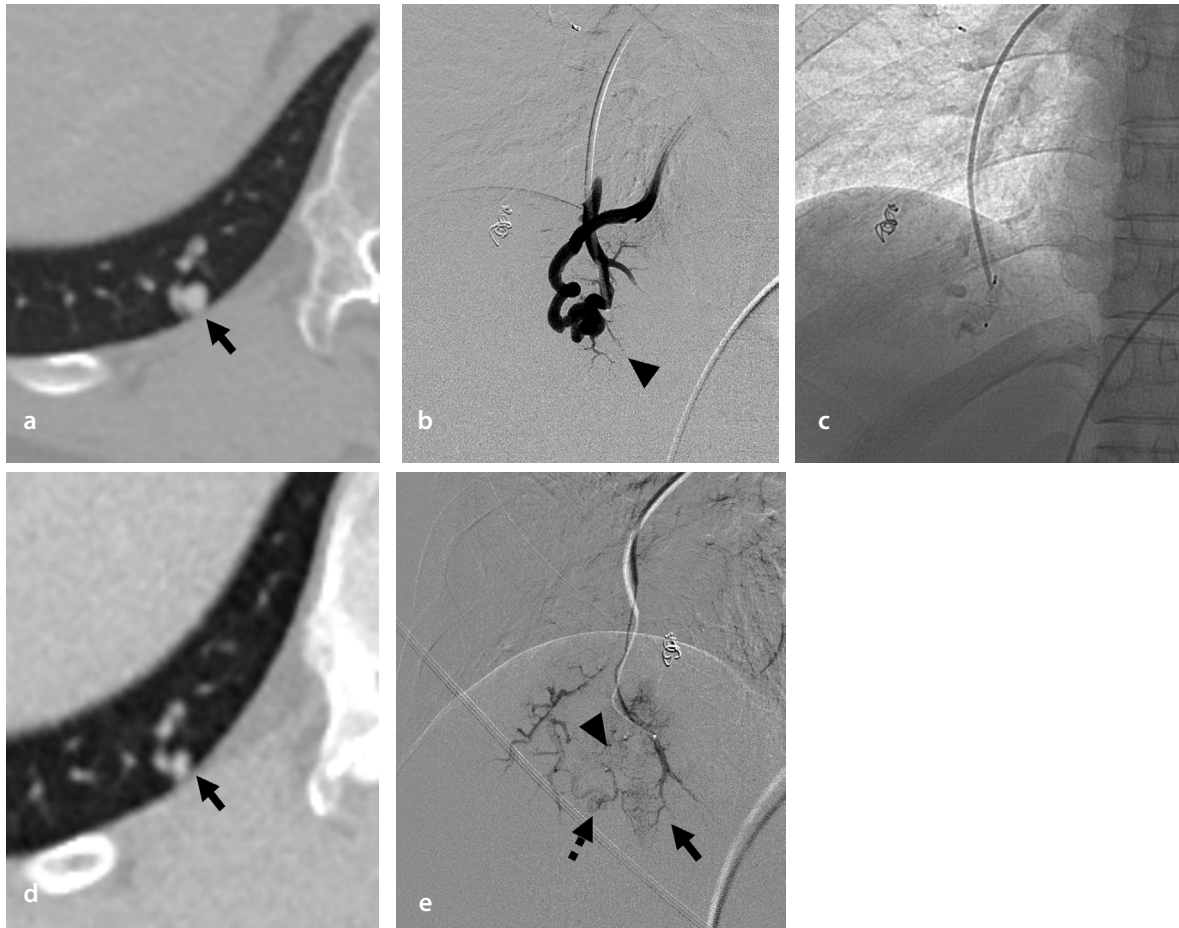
A 57-year-old woman with definite hereditary hemorrhagic telangiectasia and multiple pulmonary arteriovenous malformations (PAVM) (at least 6) in both lungs. (a) Pre-embolization computed tomography (CT) image shows a simple PAVM in the right lower lobe. The vessel diameters are as follows: feeding artery, 3.12 mm, and venous sac (arrow), 4.75 mm. (b) Angiography conducted after superselecting the distal feeding artery shows a simple PAVM. The last normal branch of the pulmonary artery is identified within the venous sac (arrowhead). (c) A 5 mm Amplatzer Vascular Plug 4 is deployed in the juxta sac-feeding artery of the PAVM. Notably, the embolization location is proximal to the last normal branch of the pulmonary artery. (d) CT performed at the 3-year follow-up shows a reduction in the diameter of the venous sac (arrow) to 3.1 mm, representing a reduction rate of 34.7%. (e) Subsequent angiography shows successful occlusion of the previously treated feeding artery (arrowhead). However, contrast opacification of the venous sac (dotted arrow) is observed due to reperfusion via adjacent pulmonary artery collateral (arrow).
